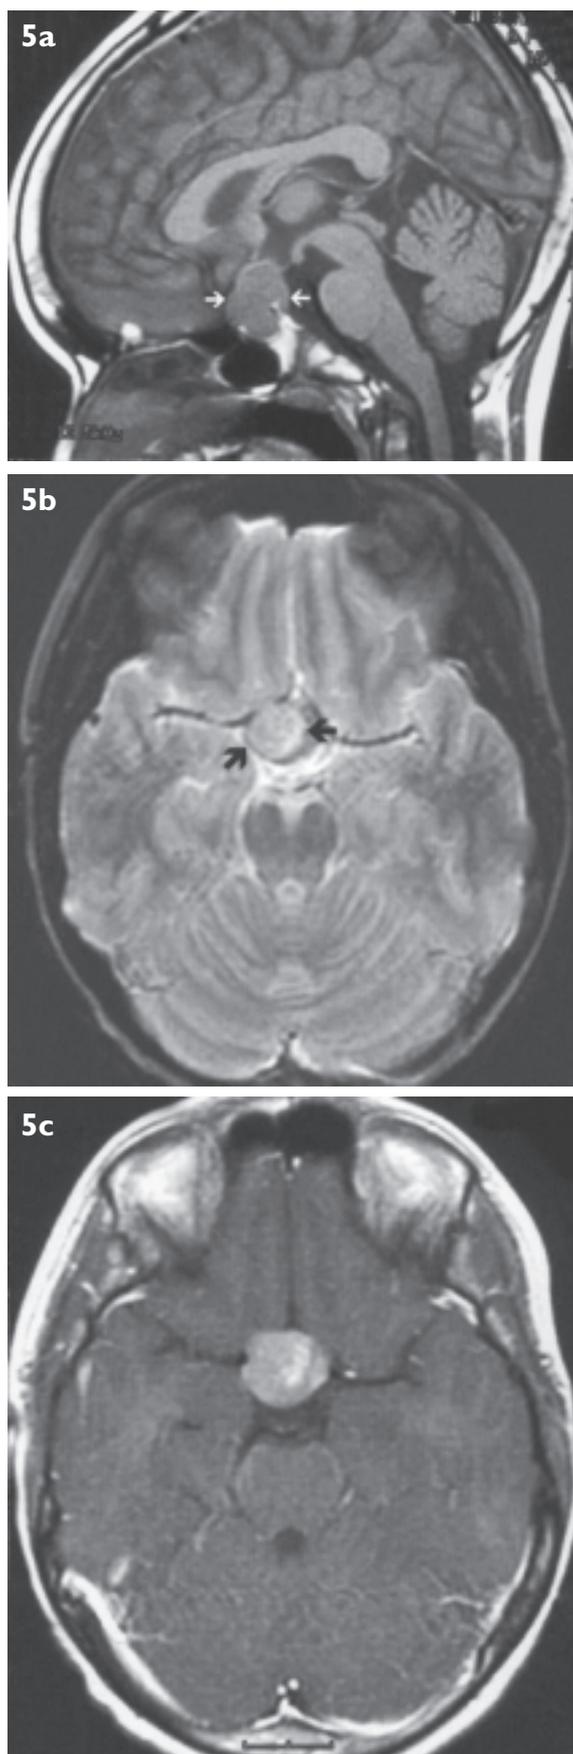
MR images of child with pituitary adenoma. (a) Unenhanced sagittal T1-weighted MR image shows hypointense mass (arrows) arising from pituitary fossa. (b) Unenhanced axial T2-weighted MR image shows slightly hyperintense mass (arrows). (c) Enhanced axial T1-weighted MR image shows enhancement of mass.
